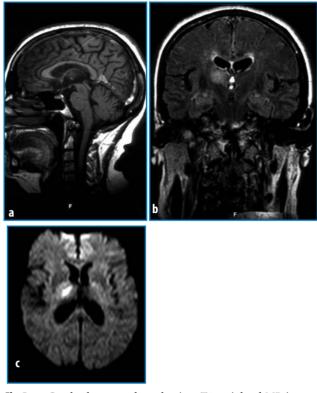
Cerebral venous thrombosis. a T1-weighted MR image obtained in the sagittal plane shows superior longitudinal and rectus sinus thrombosis. b Fluid-attenuated inversion recovery MR image obtained in the coronal plane shows a right thalamus venous infarct. c Diffusion-weighted MR image confirms a recent right thalamus venous infarct
